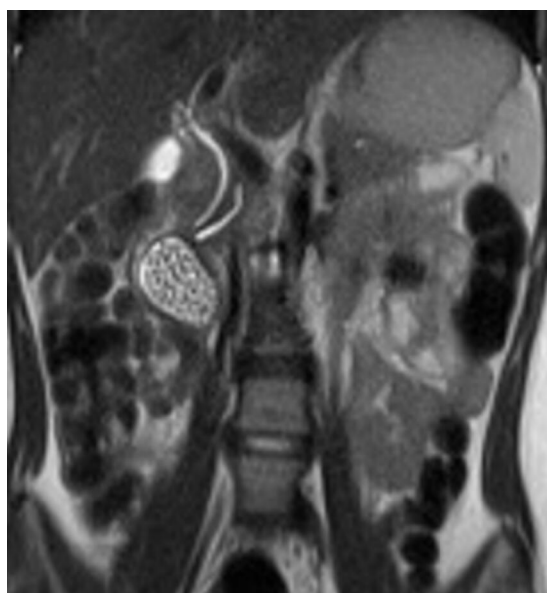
Magnetic resonance imaging showed periampullary duodenal duplication cysts filled with stones.
